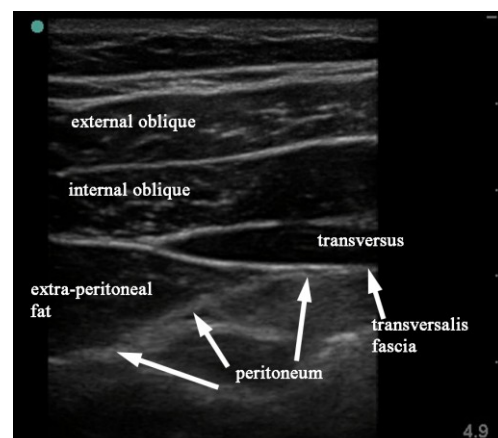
sonogram of the postero-lateral abdominal wall showing the posterior extent of transversus, underlying transversalis fascia and extra-peritoneal fat.
